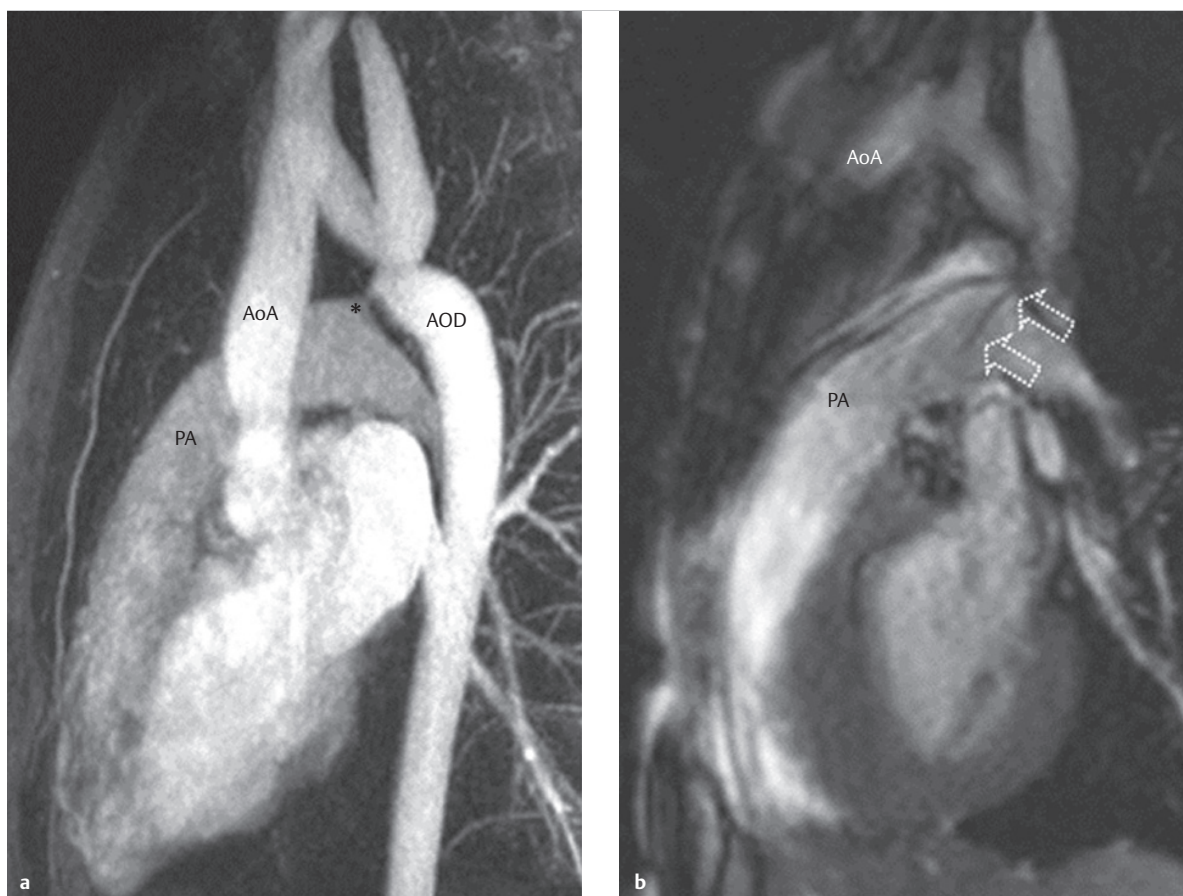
Secondary PDA. Contrast-enhanced MRA with ancillary finding of a small PDA (a, asterisk) in a 12-year-old boy who had received an MRI to depict the aortic arch based on suspicion of an aortic coarctation. Two shunts were identified: a small, silent PDA which was also detected during the cine MRI due to dephasing caused by flow acceleration (b, arrows), and a small, perimembranous VSD (► Fig. 4.11).
